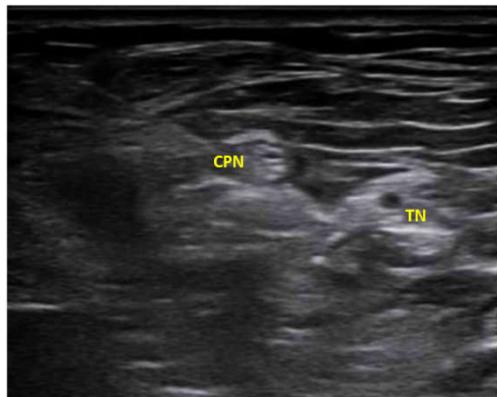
Ultrasonography image of popliteal sciatic nerve(Right side)
